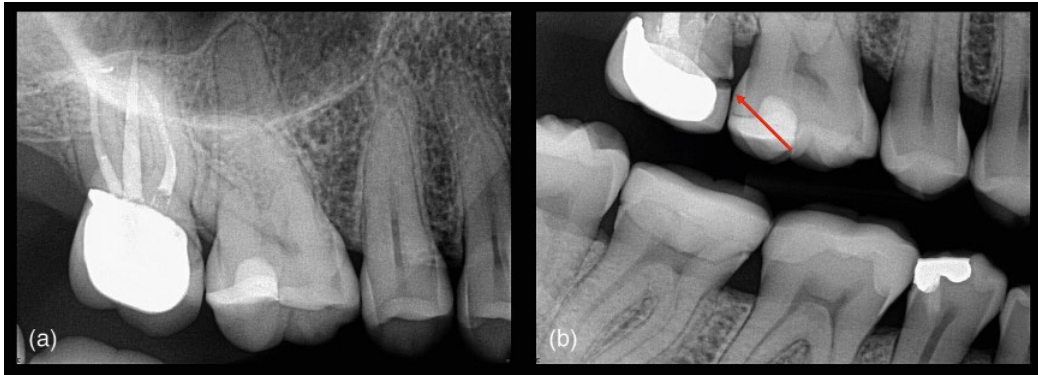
Geometric distortion. (a) Periapical radiograph of a root treated upper right molar tooth does not reveal anything untoward, (b) however, the change in the bitewing radiograph reveals a deficient crown margin (red arrow).
